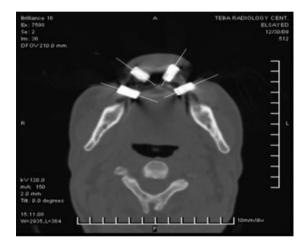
Metal plate markers in the CT images.
